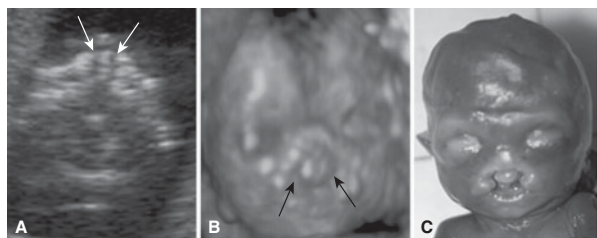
Bilateral cleft lip/palate (arrows) with flat face. (A), (B) Antenatal 2D and 3D sonograms. (C) Postnatal appearance. This fetus was affected by mosaic trisomy 8.
